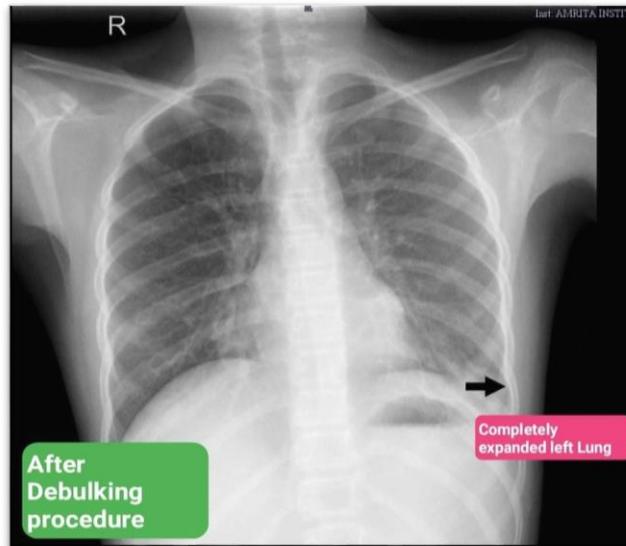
Post-op chest x-ray
